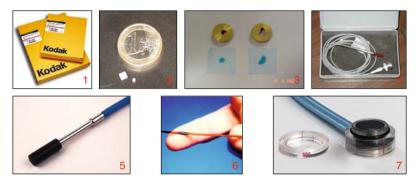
Detectors for dosimetry: (1) Radiographic film for extended dose range (EDR-2), (2) Thermoluminescent dosimeter (TLD), (3) GafchromicTM EBT (External Beam Therapy) film, (4) Hi-p silicon diode, (5) Tissue equivalent natural diamond, (6) Metal-oxide semiconductor field-effect transistor (MOSFET), (7) Plane parallel ion chamber Advanced MarkusTM
